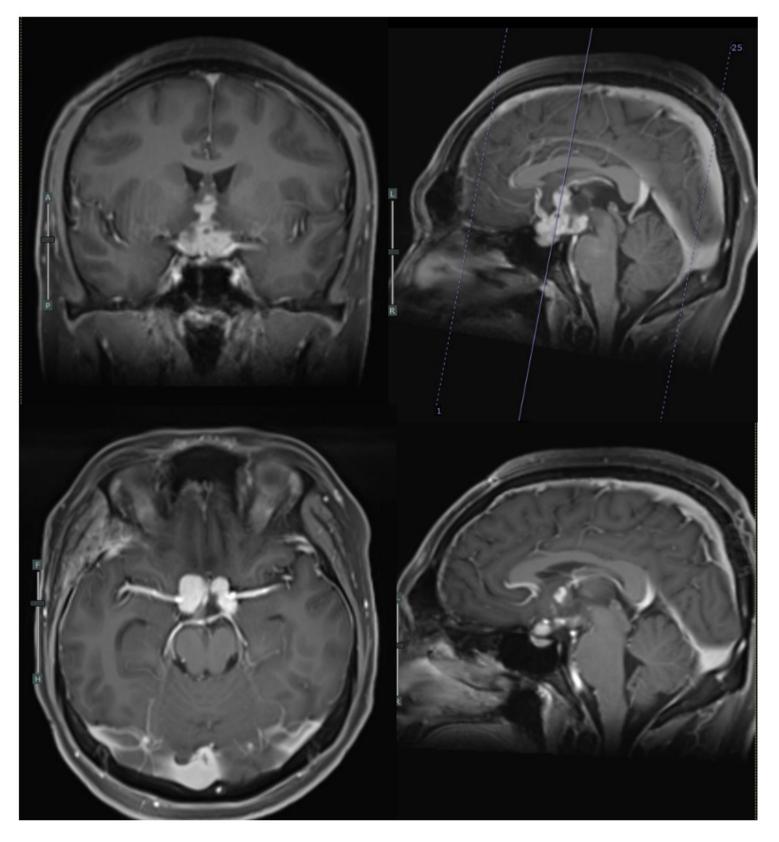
A brain MRI revealed a suprasellar solid-cystic lesion, which enhanced the contrast in the solid, sharply delimited by lobulated surface, measuring 3.0×3.6×3.0 cm. Fig 3 and 4 showed post operative M3RI evaluation
